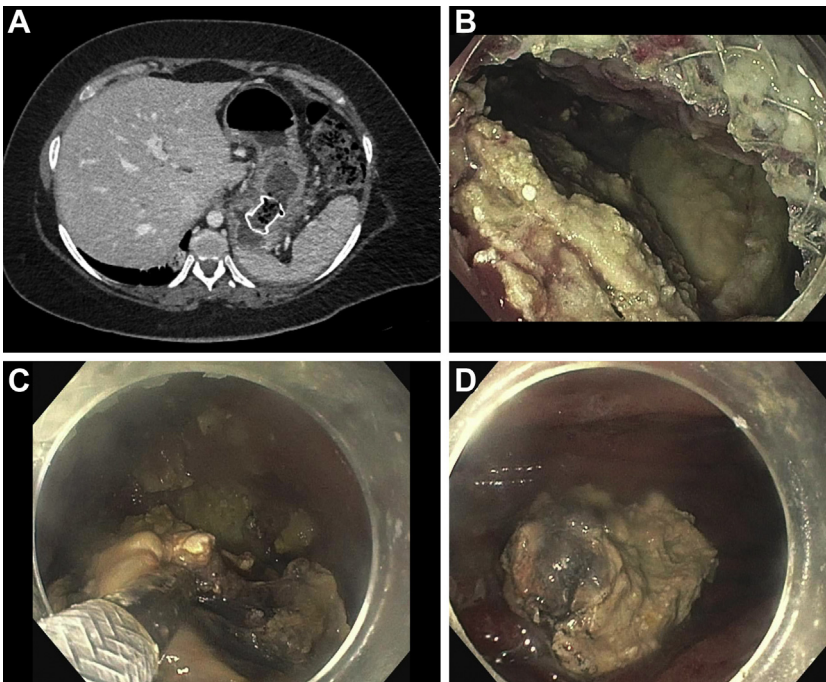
Endoscopic transgastric necrosectomy. (A) Computed tomographic imaging of an AXIOS (Boston Scientific) lumen-apposing metal stent (LAMS) placed transmurally across the posterior gastric wall into the walled-off pancreatic necrosis. (B) Endoscopic view of the walled-off pancreatic necrosis through the LAMS. (C,D) Debridement of the white necrotic pancreatic tissue and evacuation of purulence is performed through the stent.
